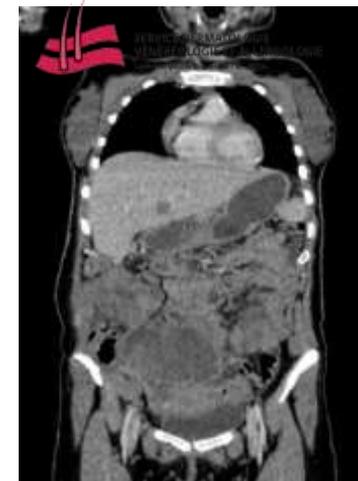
Thoraco-abdominopelvic CT showing parietal mass of the right flank
